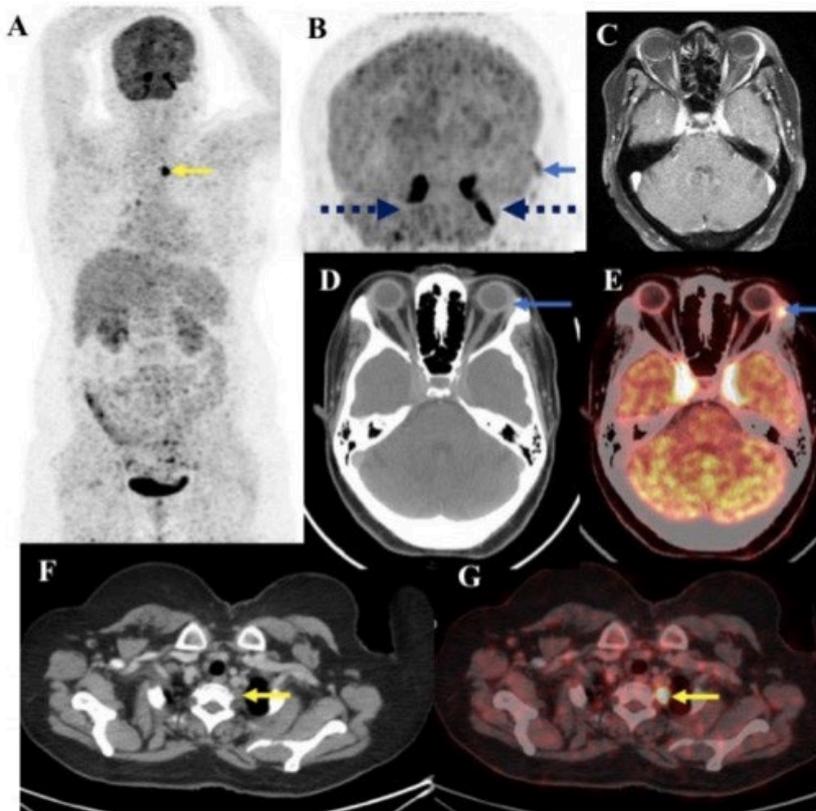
A 58-year-old female presented initially with headache and diplopia followed by numbness on left half of face, facial deviation, ptosis and bilateral diminution of vision. Maximum intensity projection (MIP) image of whole body (A) and dedicated brain image (B) with CT and fused PET/CT images showing increased FDG uptake in the bilateral cavernous sinuses (SUV_{max} 41.9; dashed arrows in B, E). T1 post contrast MRI (C) showing enhancement in the bilateral cavernous sinuses. FDG avid bulky left lacrimal gland (SUV_{max} 11.0) was noted (solid blue arrow B, D-E), biopsy from which revealed granulomatous inflammation suggestive of sarcoidosis. FDG avid centimetric paravertebral soft tissue was also noted at upper dorsal vertebral level in the whole-body MIP and transaxial fused PET/CT and CT images (SUV_{max} 24.5, yellow arrow, A, F-G)
